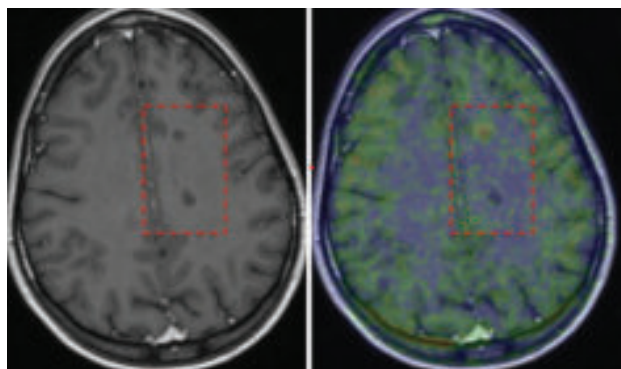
TSPO-PET imaging for neuroinflammation in multiple sclerosis. Chronic T1 lesions were differentiated in vivo using TSPO-PET. The left image shows a T1-weighted MRI image with two T1 black holes that appear comparable (no gadolinium enhancement). TSPO-PET (on the right) demonstrates that in the upper lesion, there is microglial activation, confirming this lesion as a chronic active lesion, but in the lower lesion, there is no radioligand uptake, confirming this lesion as a chronic inactive lesion.
